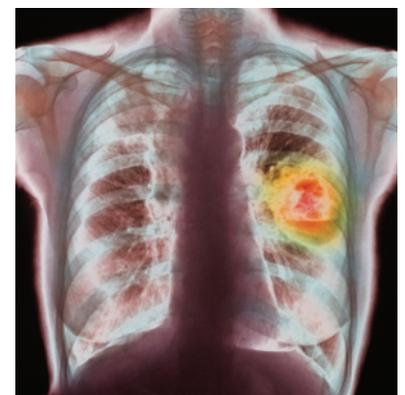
This X-ray reveals a cancerous tumour (red and yellow) in the left lung.
